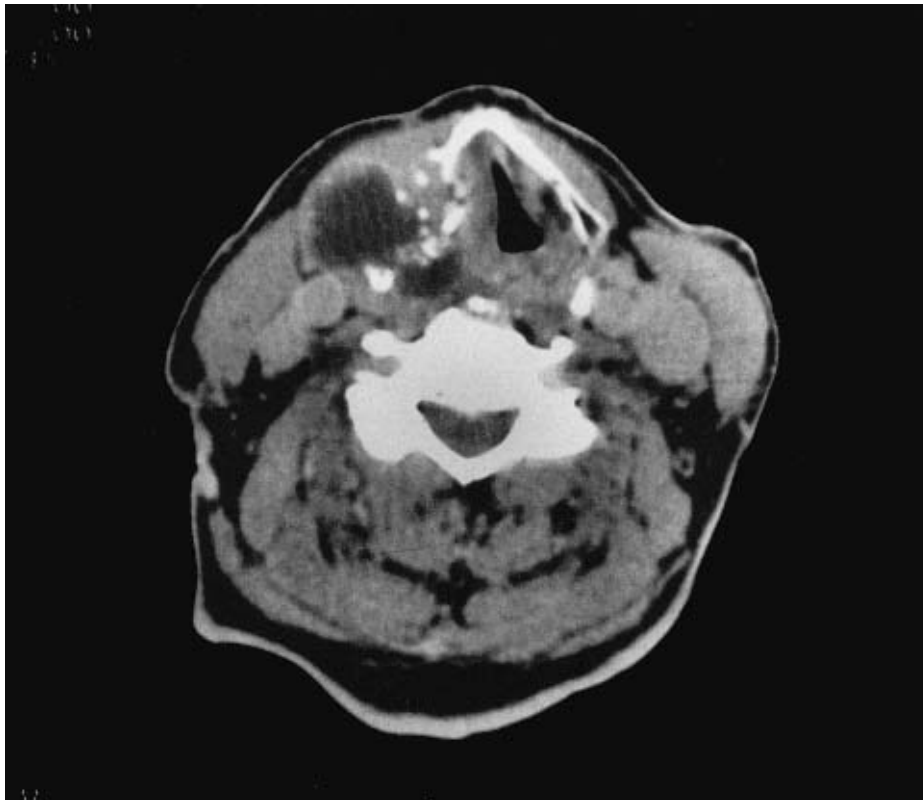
A CT image of a mass lesion destroying the posterior portion of the thyroid cartilage and demonstrating stippled to coarse ("popcorn") calcifications within the tumor.
